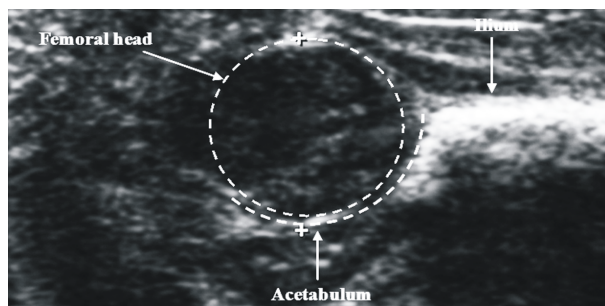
Ultrasound image of a 6-month-old fetus.
